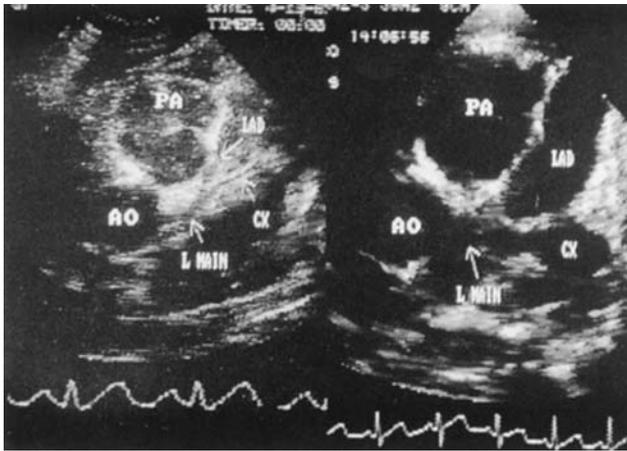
2D echocardiogram. AO indicates aorta; PA, pulmonary artery; LAD, left anterior descending coronary artery; CX, circumflex coronary artery; and L MAIN, left main coronary artery.
